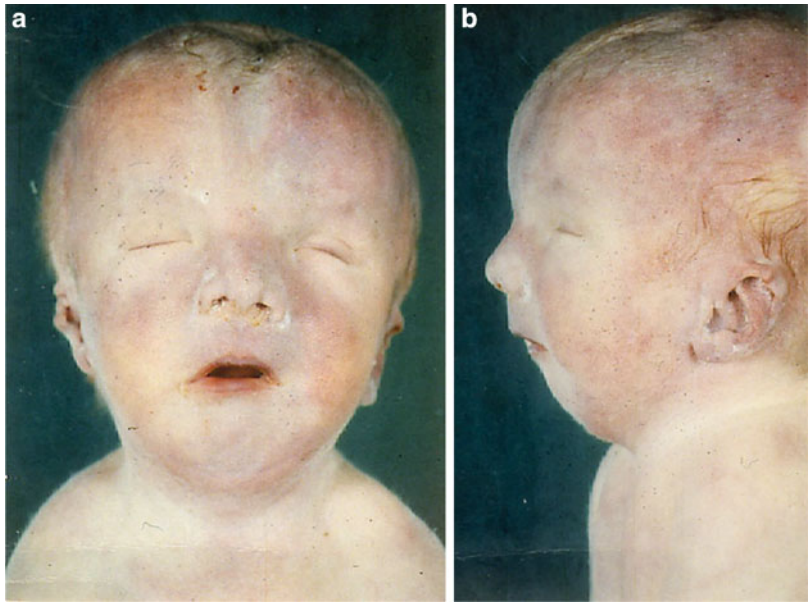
Prenatal ultrasound of this fetus showed polyhydramnios, IUGR, and flexion contractures of the knees
